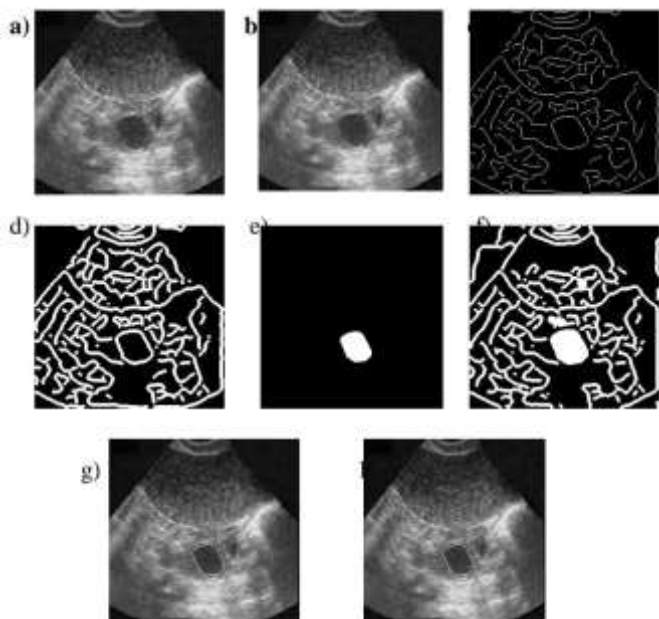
a) Input original ultrasound image of ovary, b) Image after applying Gaussian low pass filter (despeckling), c) Histogram equalised image after applying canny operator, d) Image after edge filling by dilation, e) Image after region filling, f) Final output image after applying erosion, g) Image showing recognized follicles (outlined in white) super imposed on the original image, h) Manual segmentation of follicles by the medical expert.
